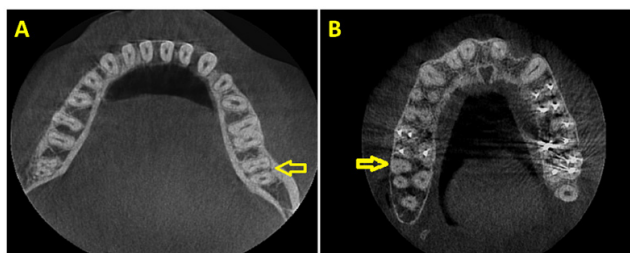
A: Axial CBCT section of a mandibular second molar with 2 roots and 2 canals in the mesial root and 1 canal in the distal root; B: Axial CBCT section of a second mesiobuccal canal of a maxillary second molar
